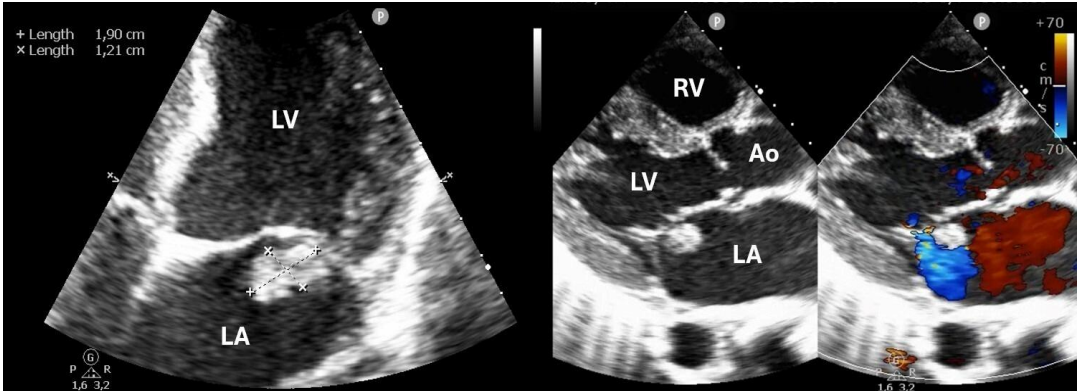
Transthoracic echocardiography (parasternal long-axis view) demonstrating a 19 × 12 mm hyperechoic oscillating vegetation on the posterior mitral leaflet (Carpentier type II prolapse) with moderate mitral regurgitation.
